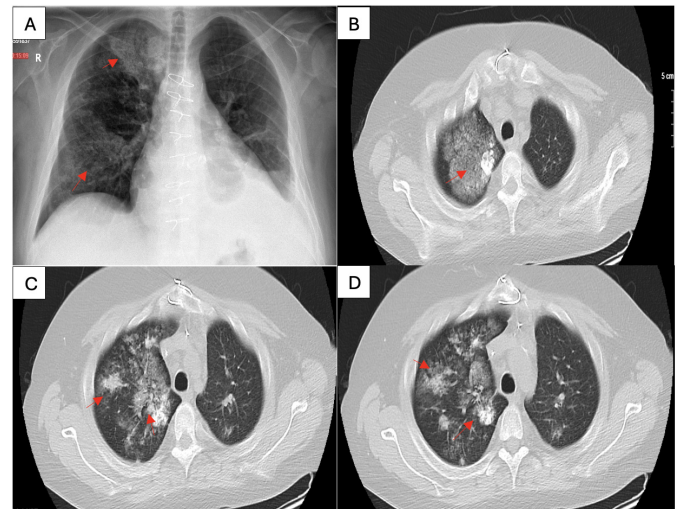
(A) In PA chest X-ray showing prominent opacities in the right lobe of the lung (red arrows). (B–D) Thorax CT showed that centrilobular ground-glass density areas and calcifications were observed in both lungs, prominent in the upper lobe of right lung (red arrows).
